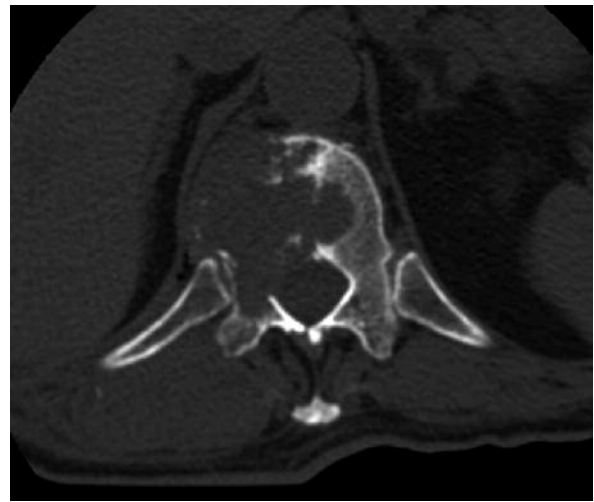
Thoracic axial CT showed a lytic lesion extending from the right side of corpus to the pedicle with cortical destruction measuring 27 cm.
